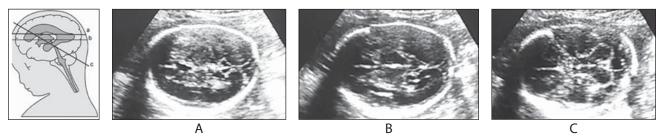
The intracranial anatomy is studied on ultrasound in three different views. First view is an axial section in which we see frontal horn, cavum septum pellucidum, atrium and choroid plexus (A). In the second axial view we can see thalamus and hyppocampal gyrus (B) and in the third view we see cerebellum and cisterna magna (C).
